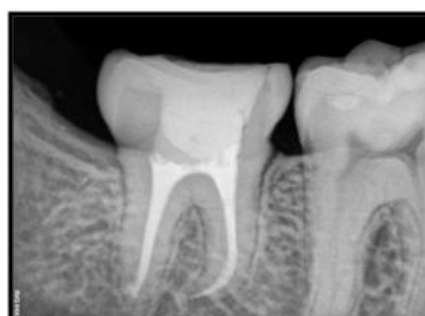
6 month follow-up radiograph
